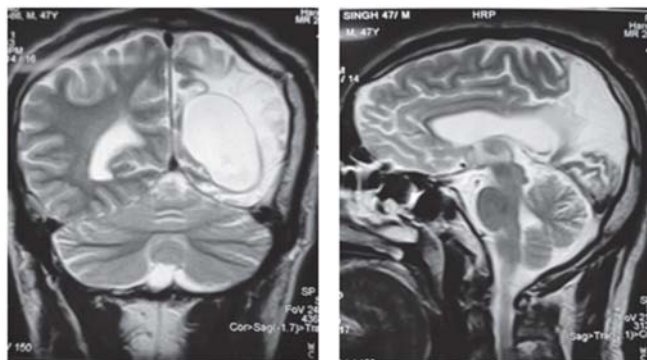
Coronal T_2 MRI Shows Left Cerebral Atrophy with Ipsilateral Ventricular Dilatation Fig 4- Sagittal T2MRI Shows Ventricular Dilatation and Myelomalacic Occipital Lobe
